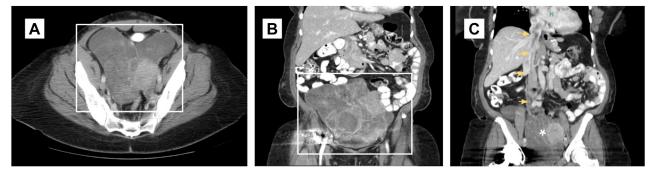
Computed tomography of the abdomen and pelvis, (A) axial and (B) coronal view, demonstrates a large globular uterus with irregular borders, consistent with fibromas (*white box*); the enlarged globular uterus with leiomyomas (*asterisk*) and IVL (*arrows*) extending from the uterus to the RA via the IVC is demonstrated in panel C. *H*, Heart.
